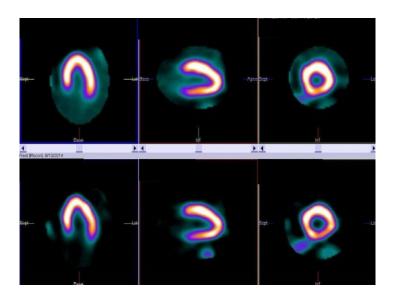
The normal finding of SPECT MPI with Tc-99m MIBI. The first row presents the transversal, sagittal, and coronal scintitomograms obtained from the reconstruction of the left chamber of the heart from the stress study, while the second row shows reconstructed scintitomograms from the rest study
